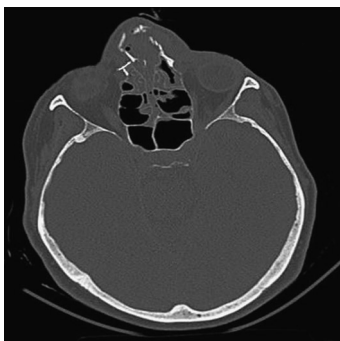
Axial computed tomographic scan demonstrating the nasal fracture.
